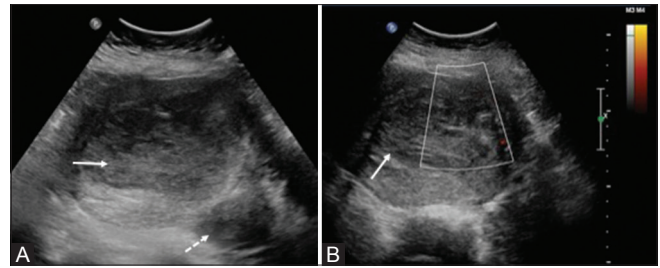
(A and B): (A) Transabdominal ultrasound of pelvis shows a relatively iso- hypoechoic mass within the endometrial cavity (white arrow). Note a subserosal fibroid in left posterolateral wall (white dotted arrow). (B) No vascularity seen on color Doppler
